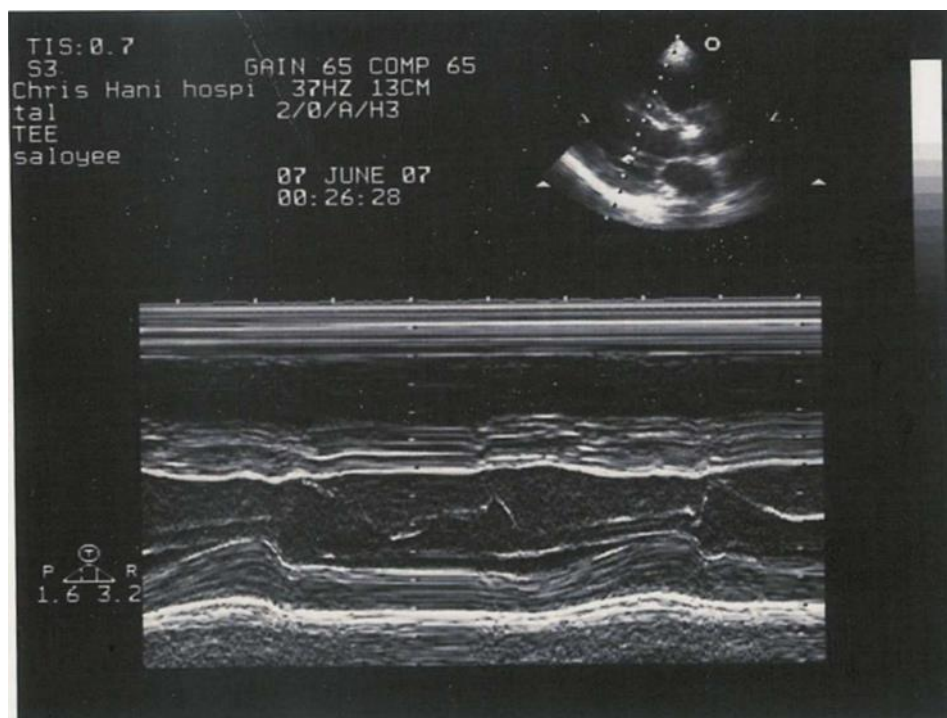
Echocardiogram used to assess cardiac structure and function. The picture shows internal dimensions and posterior wall thickness of the left ventricle (Majane, 2009). A- Left ventricular end diastolic (LVED) diameter; B- Left ventricular end systolic (LVES) diameter; C-Left ventricular end systolic posterior wall thickness; D-Left ventricular end diastolic posterior wall thickness; E-Left ventricular end diastolic septal wall thickness; F-Left ventricular end systolic septal wall thickness (Nunez *et al.*, 2005).
